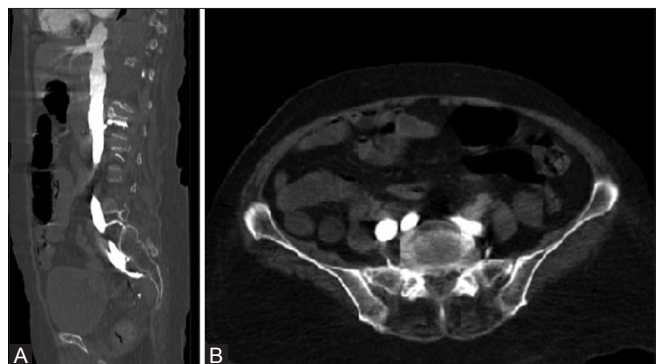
(A and B): (A) CT scan of abdomen with contrast enhancement. A. Sagittal reformatted image demonstrates severe reflux into inferior vena cava, iliac and epidural veins. Regurgitation into renal veins is appreciated. (B) Axial view shows reflux into iliac and epidural veins on both sides
